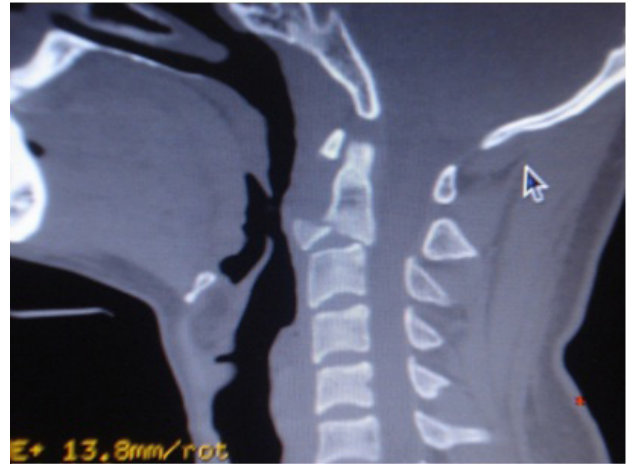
CT cervical spine showing tear drop fracture fragment.
